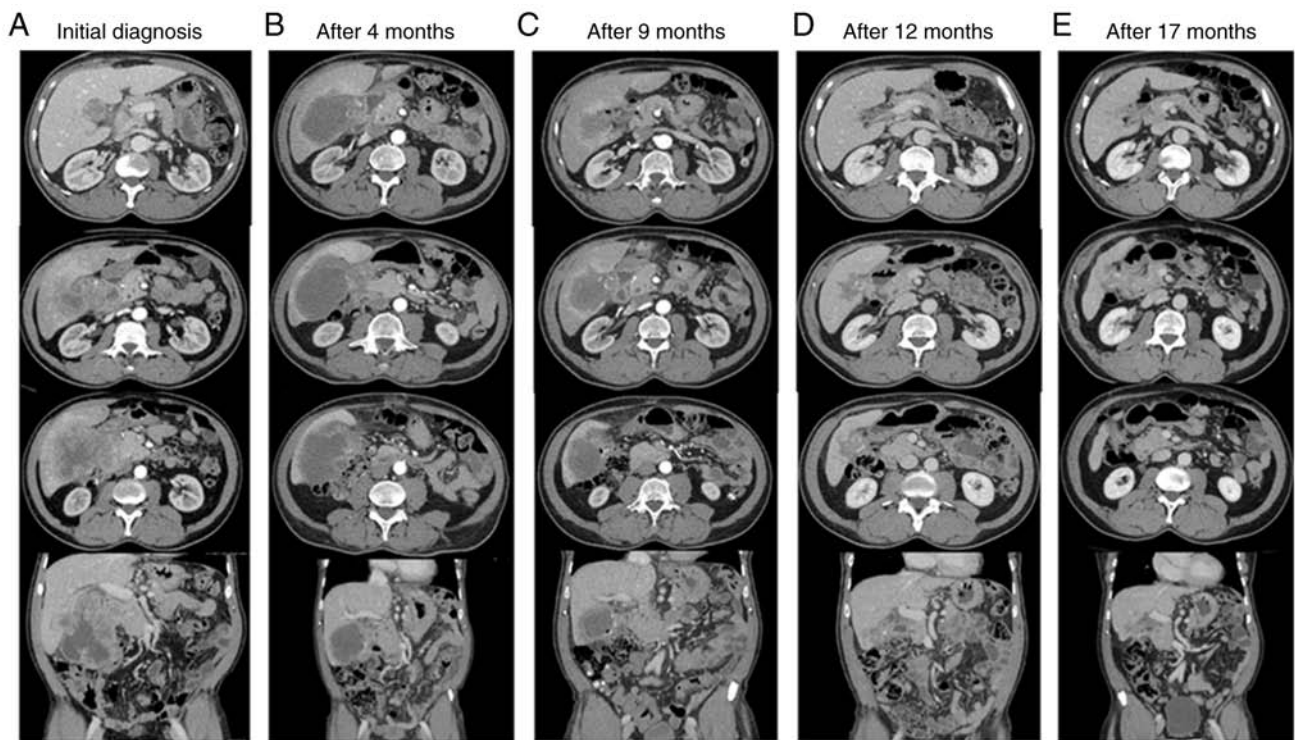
CT scan evolution over the course of 17 months of treatment. Enhanced CT scans showing a gallbladder lesion infiltrating the hepatic pedicle, the head of the pancreas, colonic hepatic flexure and liver lesions during the course of treatment, with a progressive reduction in the size of the lesion and the infiltrative component. (A) First three images: Axial CT scans showing the initial size of the lesion, infiltration of the hepatic pedicle, and impact on the head of the pancreas. Fourth image: Coronal CT scan highlighting the colonic hepatic flexure and liver lesions. (B) First three images: Axial CT scans showing a slight reduction in the lesion size, decreased infiltration of the hepatic pedicle and reduced impact on the head of the pancreas. Fourth image: Coronal CT scan showing less pronounced lesions in the liver. (C) First three images: Axial CT scans showing a marked reduction in lesion size, further decreased infiltration of the hepatic pedicle and minimal impact on the head of the pancreas. Fourth image: Coronal CT scan showing smaller liver lesions. (D) First three images: Axial CT scans showing the lesion was almost completely reduced, minimal to no infiltration of the hepatic pedicle and negligible impact on the head of the pancreas. Fourth image: Coronal CT scan showing near resolution of liver lesions. (E) First three images: Axial CT scans showing the lesion was almost completely reduced, minimal to no infiltration of the hepatic pedicle and negligible impact on the head of the pancreas. Fourth image: Coronal CT scan showing near resolution of liver lesions.
